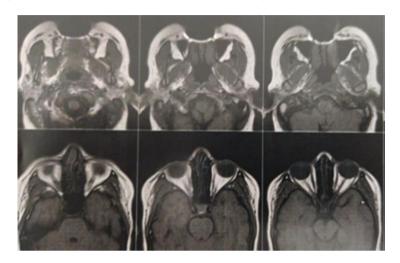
Magnetic resonance imaging of the malar region on the right and left sides
